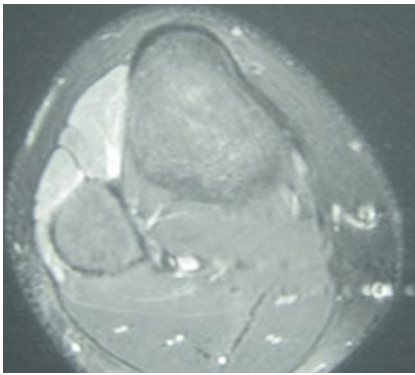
Axial magnetic resonance imaging shows increased uptake in the peroneal muscles consistent with compression of the common peroneal nerve.
